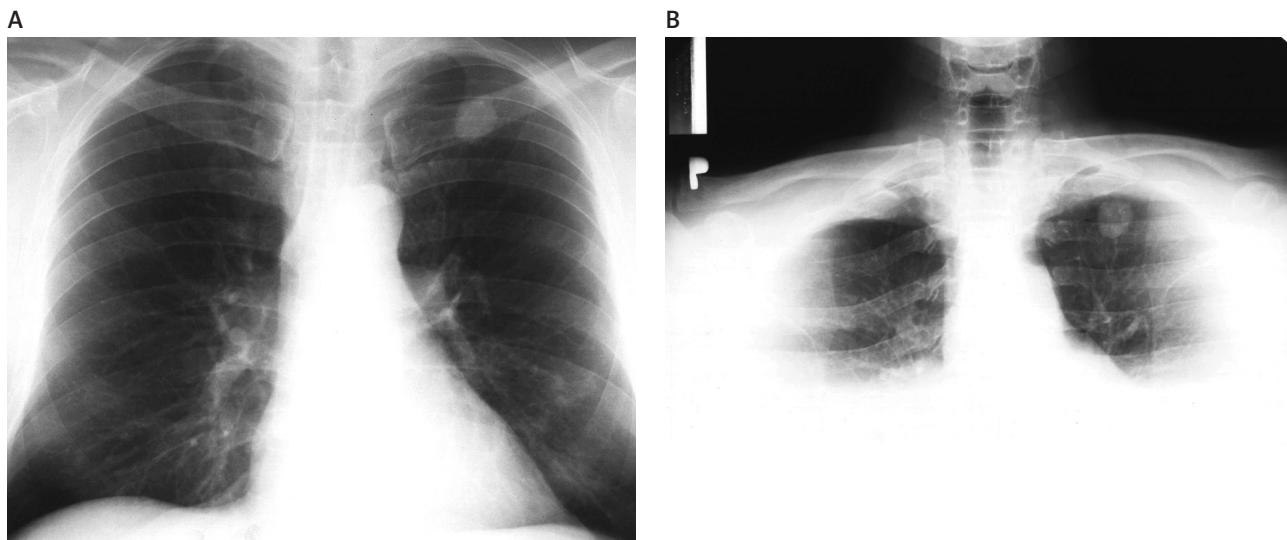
Chest X-ray examination showed round, smooth, well-defined lesion in anterior-posterior (A) and oblique (B) projection
